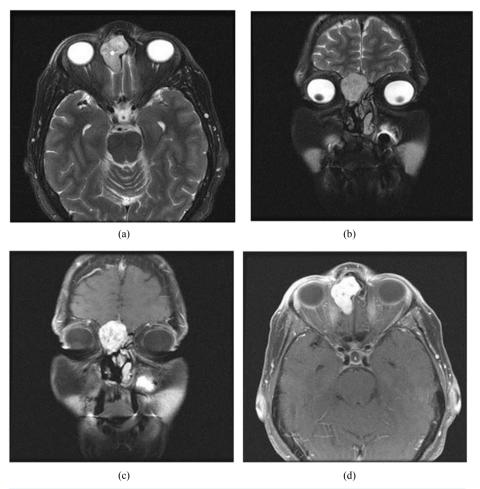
Right ethmoidal sinonasal schwannoma. Axial (a) and coronal (b) T2-weighted facial MRI images demonstrate a hyperintense mass centered in the right anterior ethmoid air cells. The mass characteristically enhances intensely on post-gadolinium axial (c) and coronal (d) T1-weighted images. Biopsy confirmed the diagnosis of sinonasal schwannoma.
